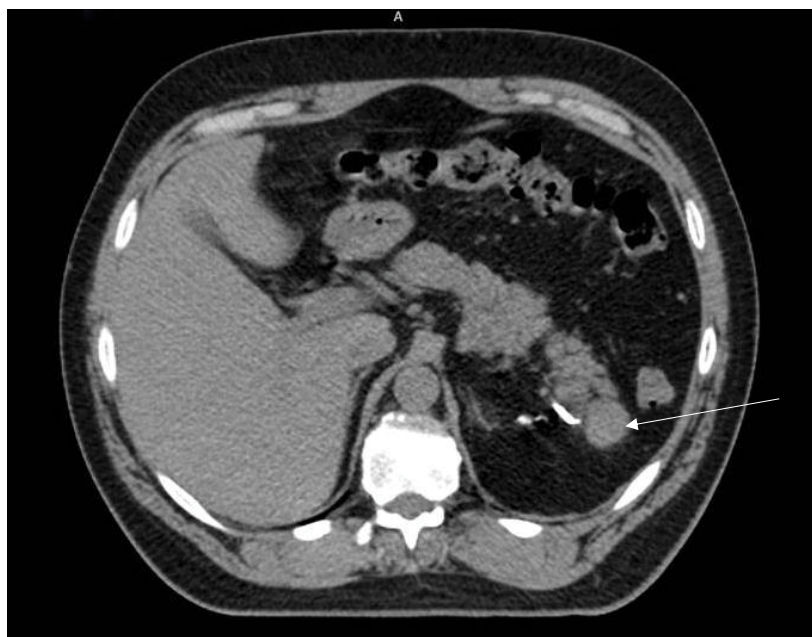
CT scan imaging of the accessory spleen attached to the pancreatic tail.
